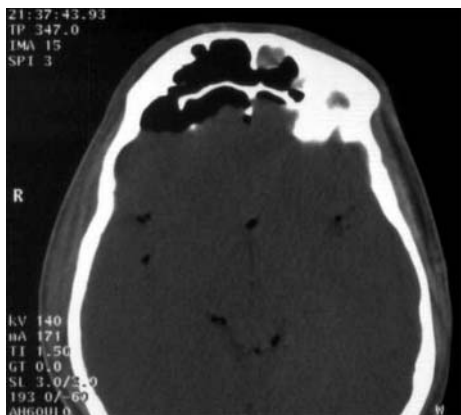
Computed tomogram of the head showing pneumocephalus with fracture of posterior wall of frontal sinus.
